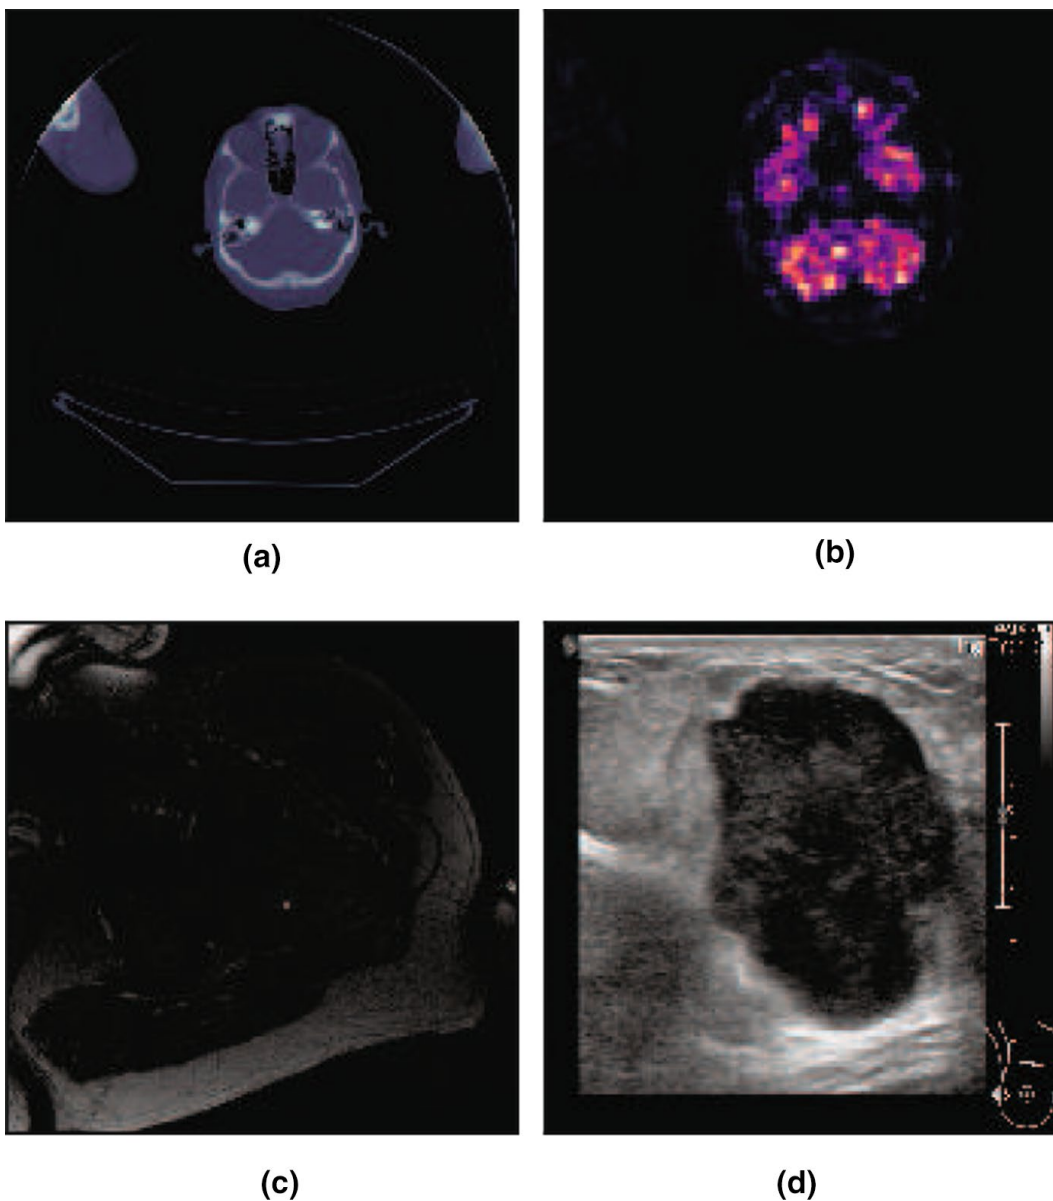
Different types of medial image [13]. a CT image. b PET image. c MR image and d US image
